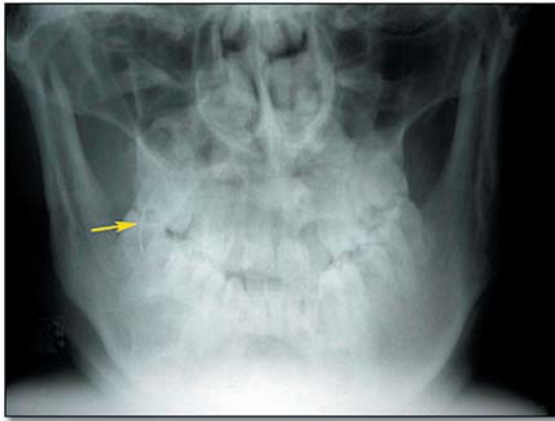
Skull x-ray (PA) showing a crescent-shaped radiopacity on the right molar teeth (arrow).
